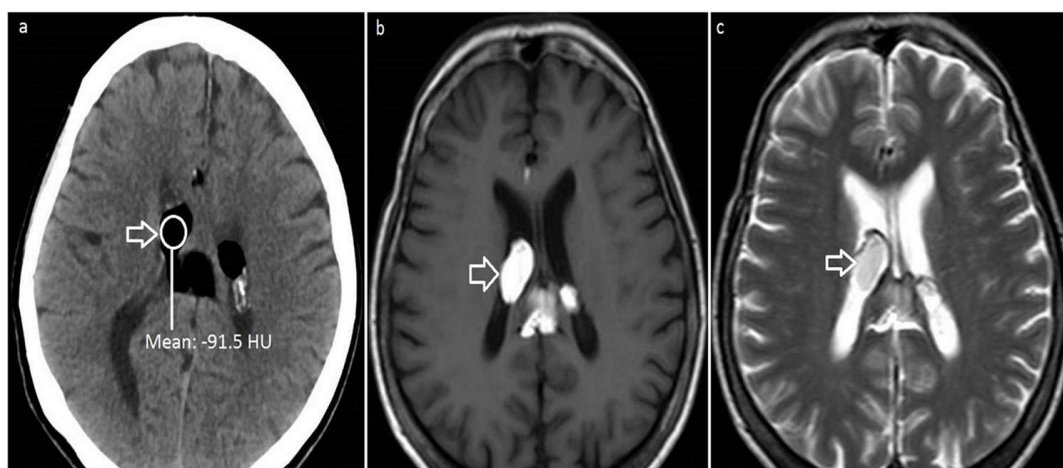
Image (a) shows cranial computed tomography. There is a homogenously hypodense lesion measuring 33 mm x 30 mm in the lateral and third ventricles with about -101 to -110 Hounsfield unit. Image (b) and (c) show magnetic resonance imaging with hyperintense mass lesion in lateral ventricle (T1-weighted and T2-weighted images, respectively).
